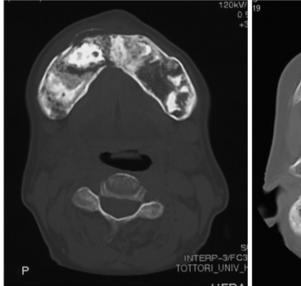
Computed tomography images revealed buccal-lingual bony expansion of bilateral mandible and radio-opaque masses peripherally lined by a radiolucent layer at right mandible and left maxilla. Both sides of maxillary sinuses were filled with bony lesion.
